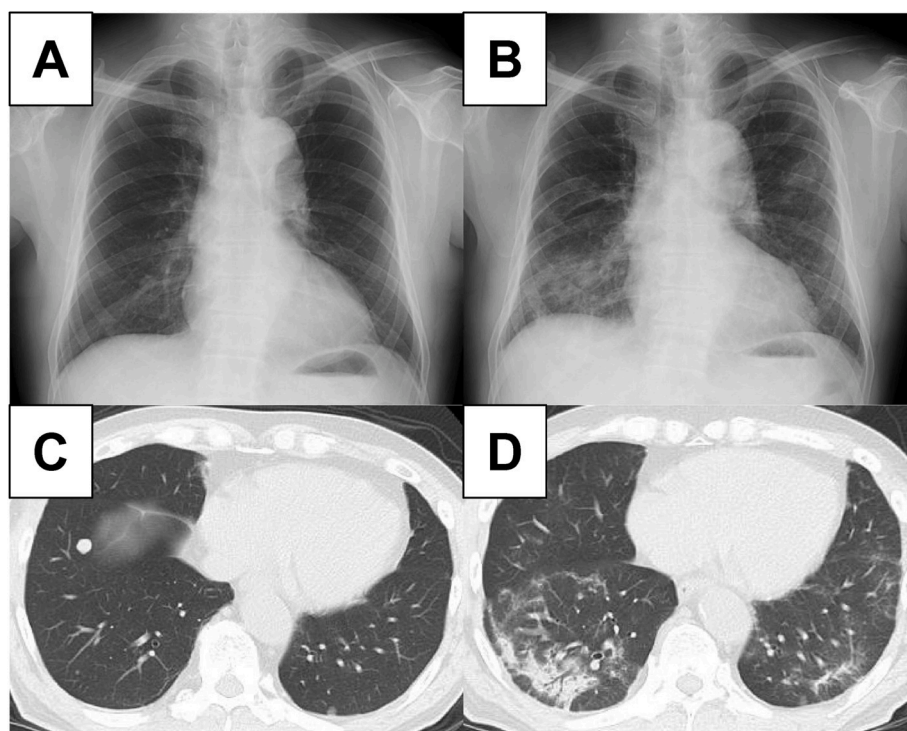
Chest radiography and computed tomography findings before and after pazopanib treatment.
